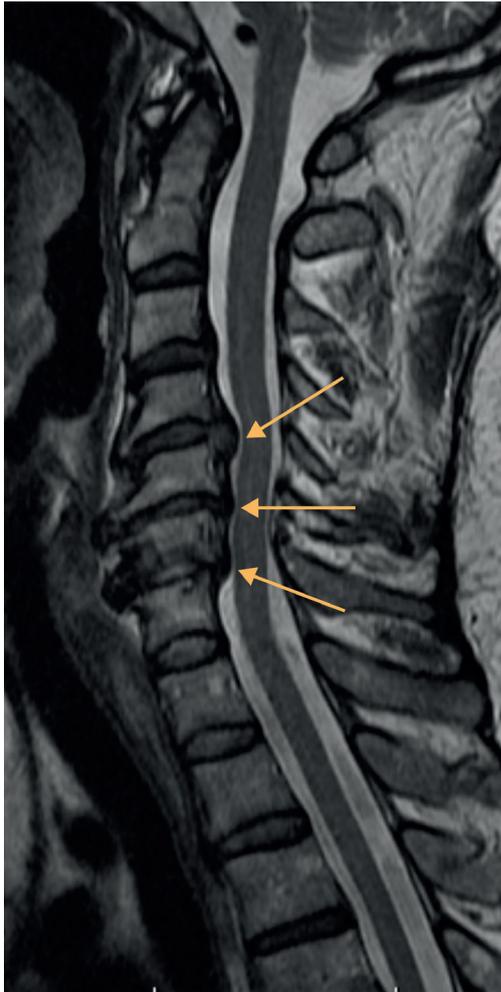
Sagittal T2-weighted magnetic resonance (MR) image of the cervical spine in a patient with myelopathy shows multi-level disc herniations compressing the anterior surface of the spinal cord (arrows)
